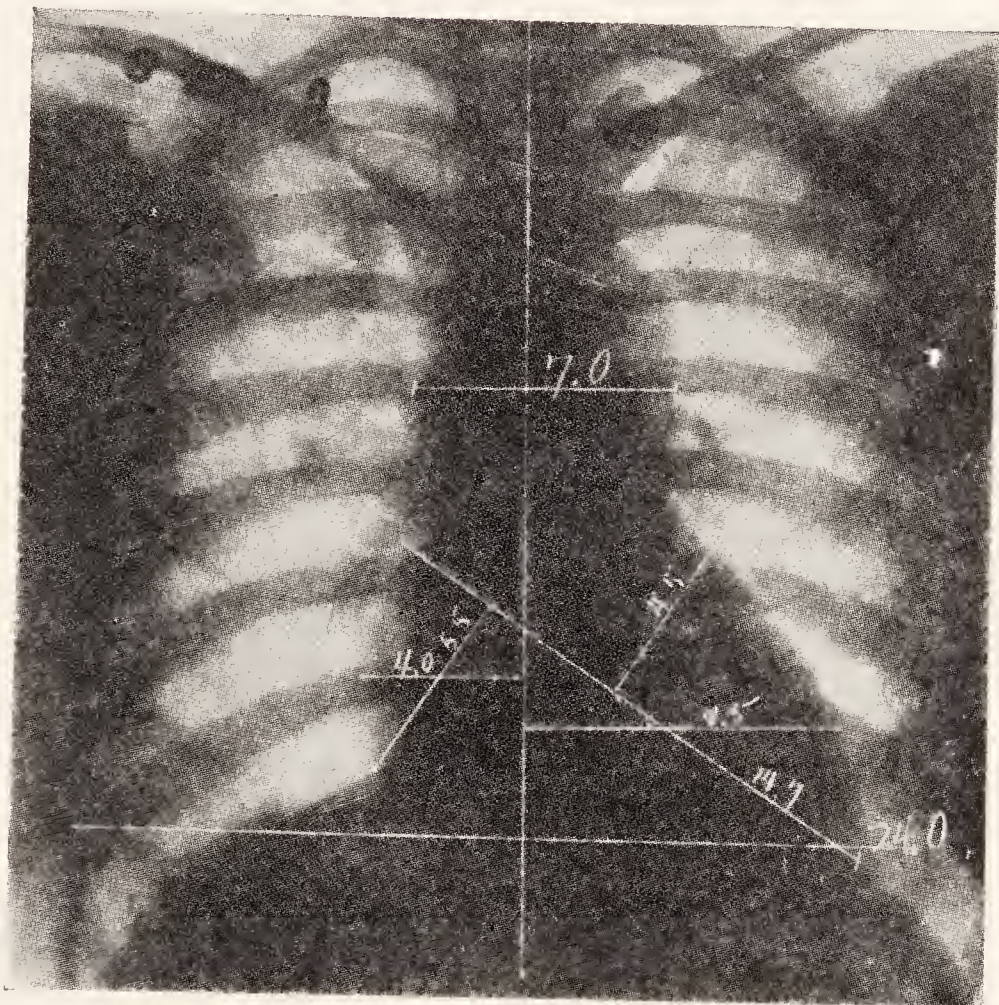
Necropsy 4251. Chronic glomerulo-nephritis with hypertrophy of the heart and subacute pericarditis. X-ray shows the heart apparently slightly enlarged. There is unusual angulation in the border of the left ventricle; otherwise the shape of the heart is not abnormal. Supracardiac dullness abnormally wide, and aortic area shows generalized increase in size, suggesting a diffuse dilatation. (Roentgenological Department, Massachusetts General Hospital.)
